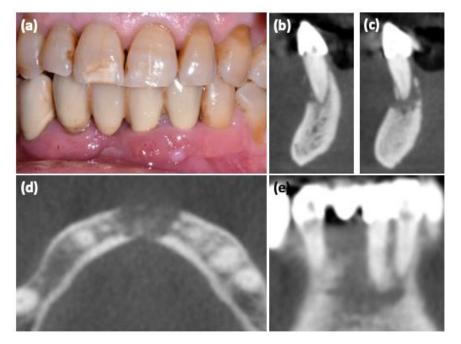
MRONJ stage I, lower jaw: (a) clinical view; (b-e) computed tomography scan sections.
